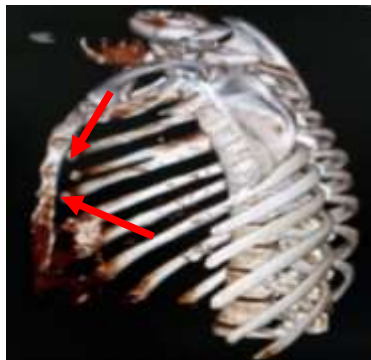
Figure No- 2.04 - Left lateral view, 3-D CT reconstructed image of a 38 years old female showing bifurcated anterior end of right 4th rib.
